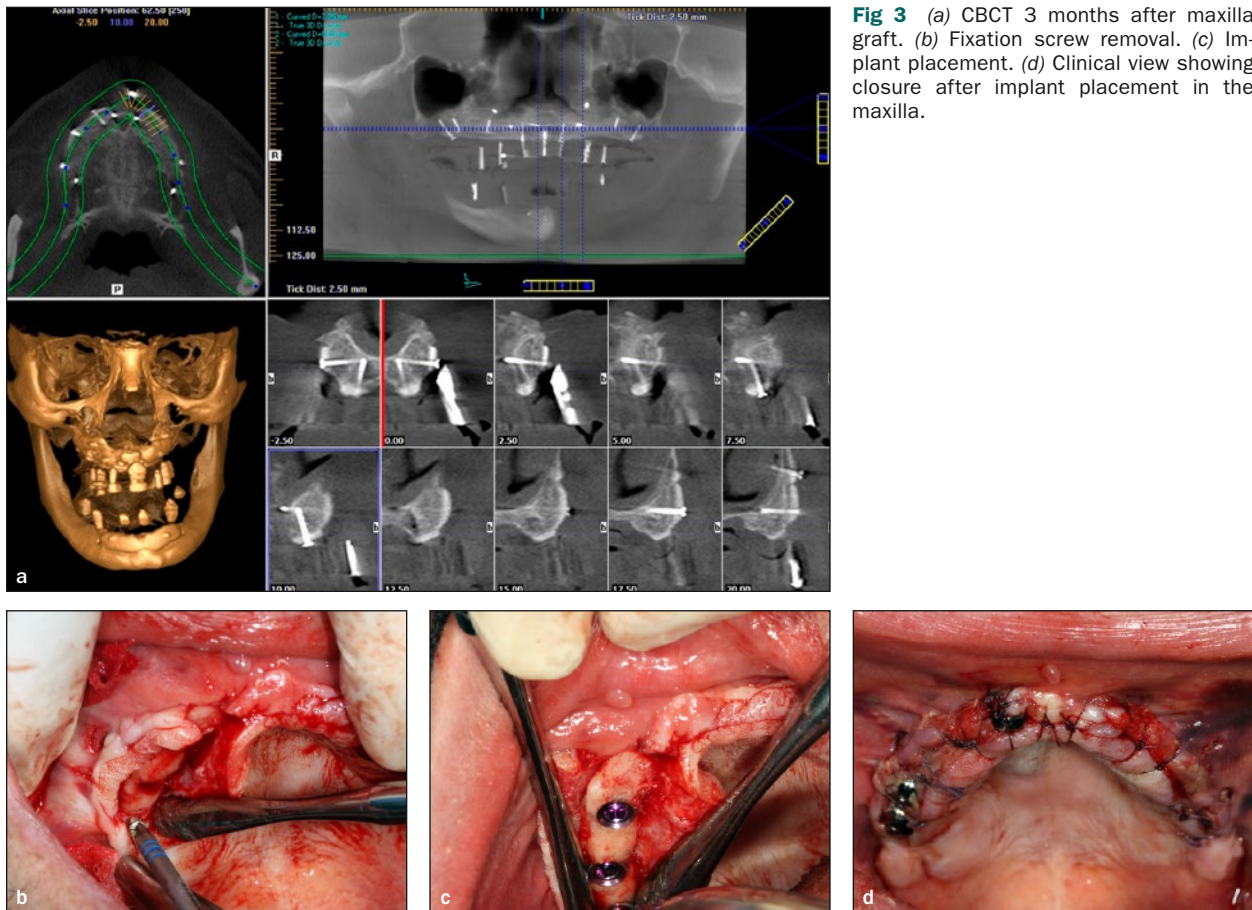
(a) CBCT 3 months after maxilla graft. (b) Fixation screw removal. (c) Implant placement. (d) Clinical view showing closure after implant placement in the maxilla.
